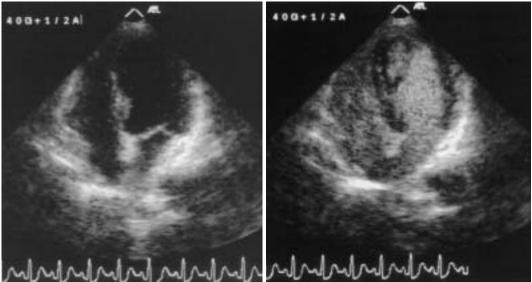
Representative example of a good quality image Images show the diastolic apical four-chamber view with *(right)* and withou *(left)* contrast medium when the patient s heart rate was 138 beats/min. The endocardial border was clearly delineated with contrast medium.
